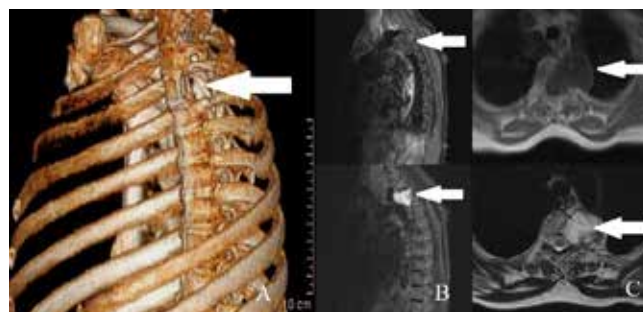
(A) The three-dimensional CT scan showing a cystic and expanding mass (white arrows) is seen at T4 level with the destruction of the vertebral body, (B) Coronal, and (C) axial MRI scan of thoracic T4 vertebral level (white arrows).
